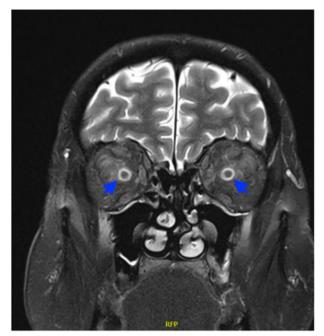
MRI (T2-sequence with fat suppression and gadolinium) demonstrating perineural enhancement of both optic nerves.
